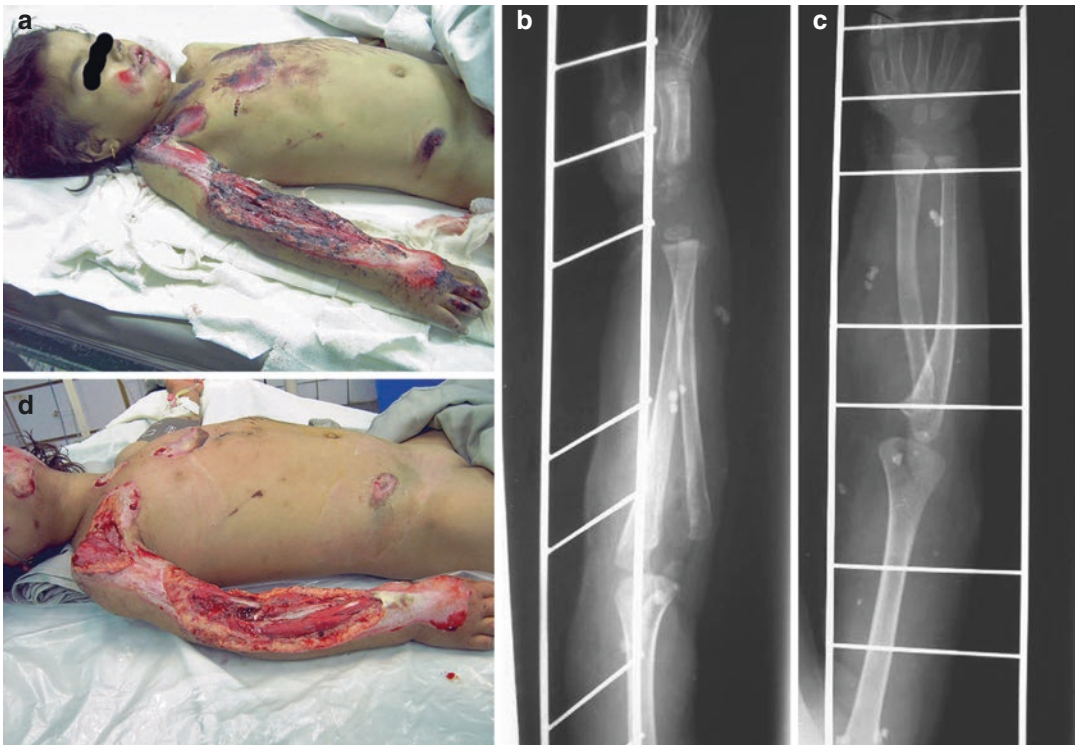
(a) Child with crush injury to torso and right upper extremity before debridement. (b, c) X-ray showing proximal radial dissociation and radiodense particulate matter. (d) After debridement
